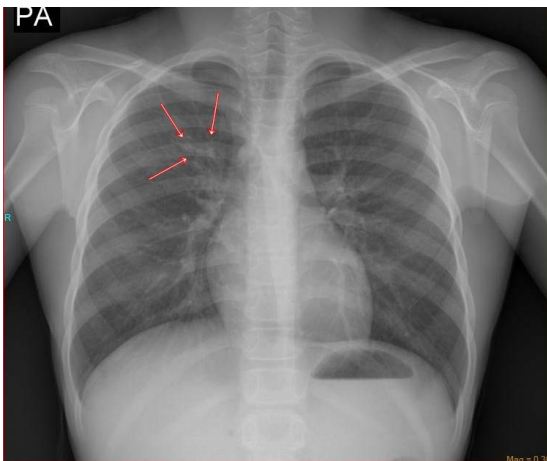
Chest X-ray showing the presence of ground glass view on superior segment of the right lung (red arrows).
